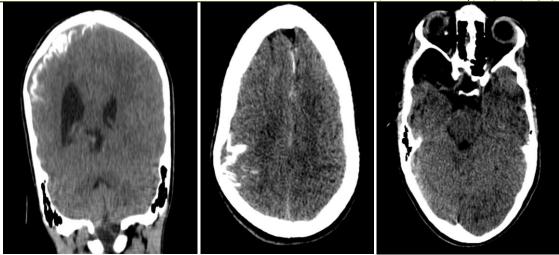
Non-contrast CT scan showing gyriform cortical calcifications in the right fronto-temporo-parietal region with ipsilateral cortical atrophy and a right temporal arachnoid cyst
